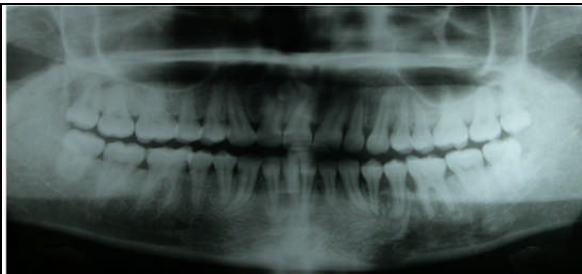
OPG radiograph of the patient after treatment
